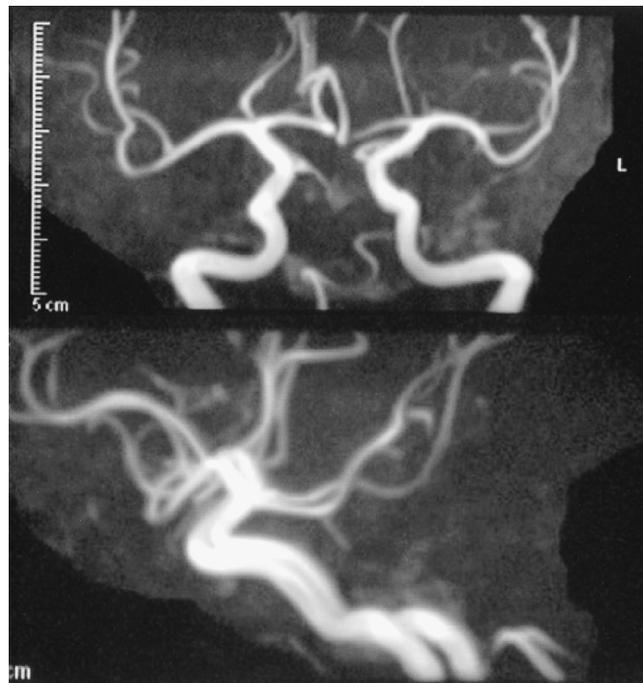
Magnetic resonance angiograms (Upper : A-P view, Lower : Lateral view) do not clearly depict the distal part of the basilar artery. However, MRI images clearly show the bilateral posterior cerebral arteries via the posterior communicating arteries.
